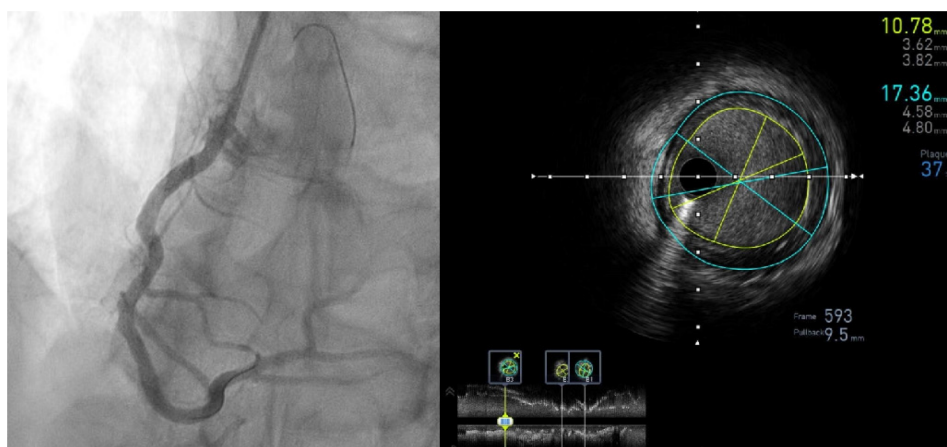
Intravascular ultrasound pull-back of a right coronary artery post stent implantation. Stent expansion is assessed and the minimal lumen area measured in different cross-sections (bottom longitudinal view) while the plaque burden at the distal reference (B3) is shown on the cross sectional frame 593 (lumen area 10.78 mm², vessel area 17.36 mm², plaque burden 37%).
